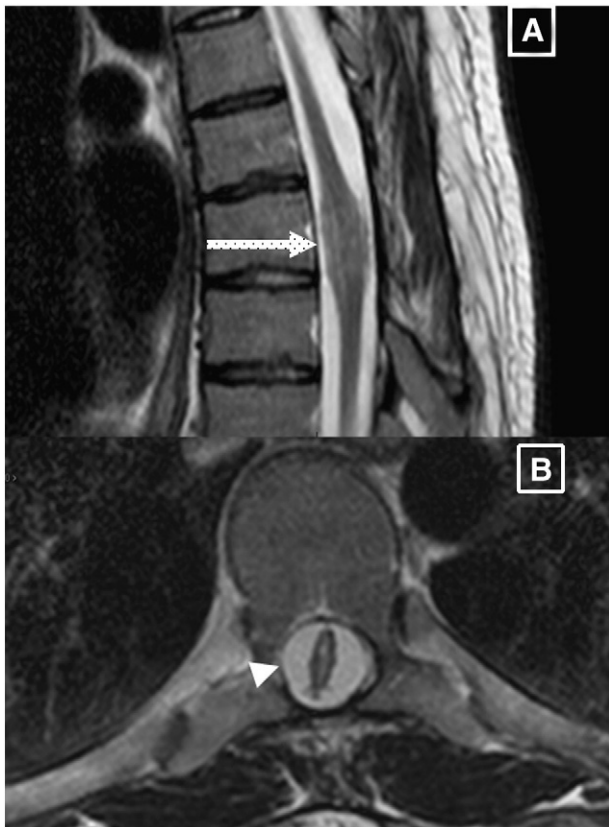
(A) T2-weighted acquisition in the sagittal plane, showing a pseudo-tumefactive shape (white arrow) of the spinal cord at 12 months control; (B) T2-weighted acquisition in the axial plane (same patient and same time of exam), showing the band-like morphology (white arrowhead) distortion responsible of the sagittal appearance without evidence of spinal cord tumefaction or swelling at the site of the implant (see posterior surgical breach).
